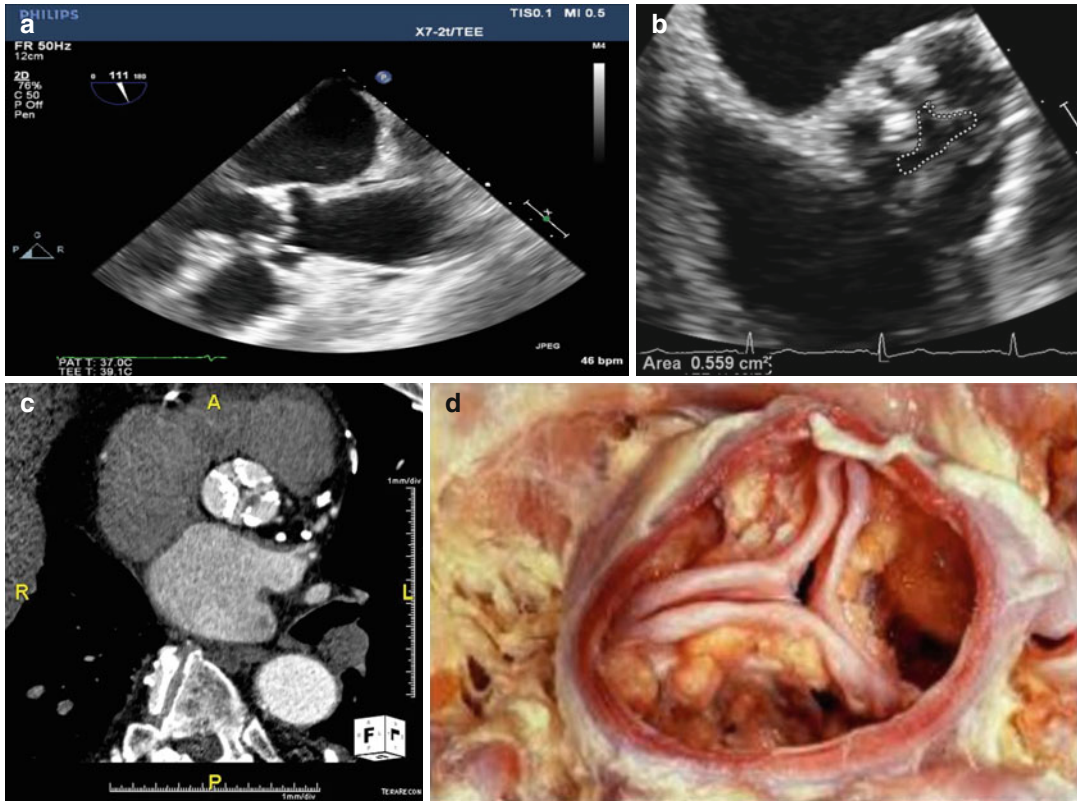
Parasternal long (*top left, a*) and short (*top right, b*) axis transesophageal echocardiography showing reduced excursion aortic leaflets due to severe aortic
